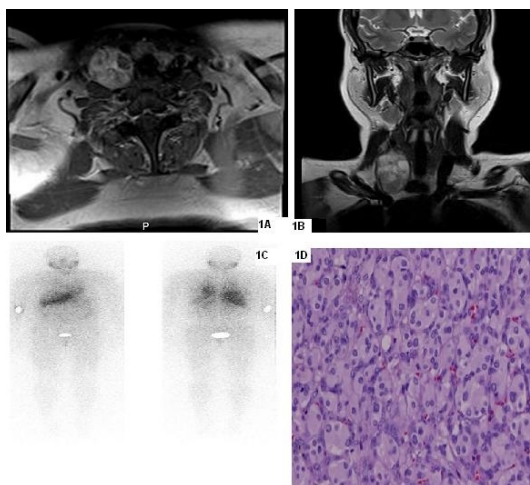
Axial section of MRI shows heterogenous contrasted mass on the right.
